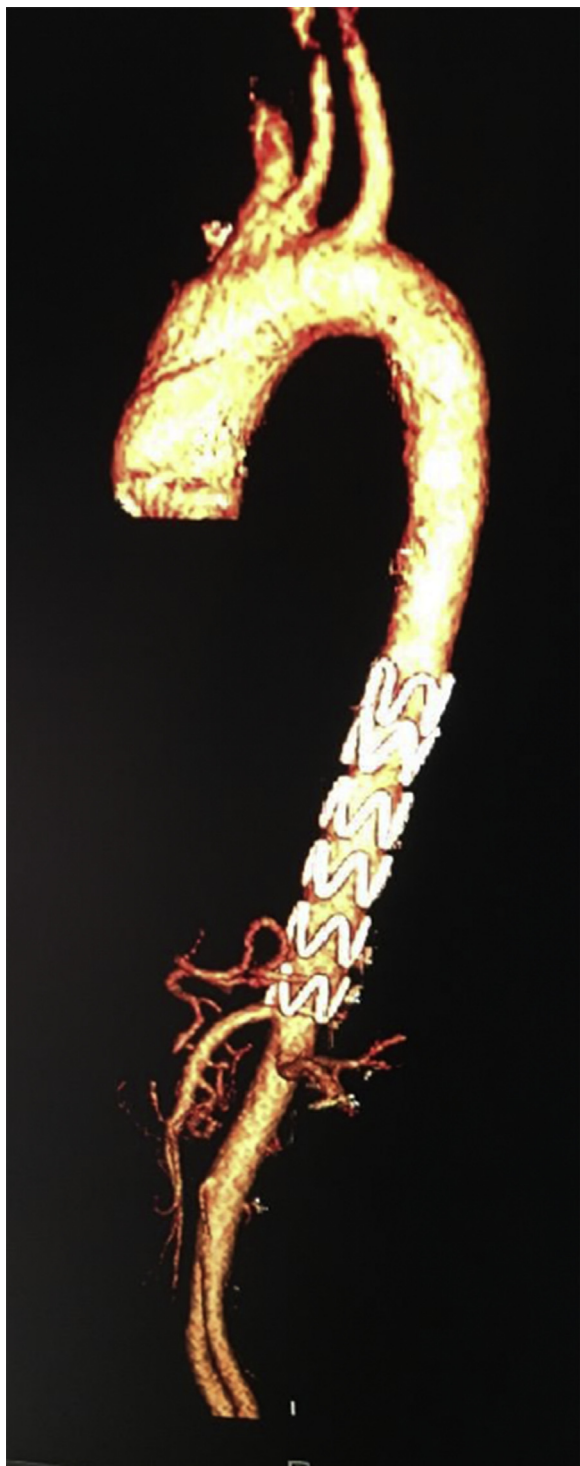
The 6-month follow-up computed tomography (CT) scan.
